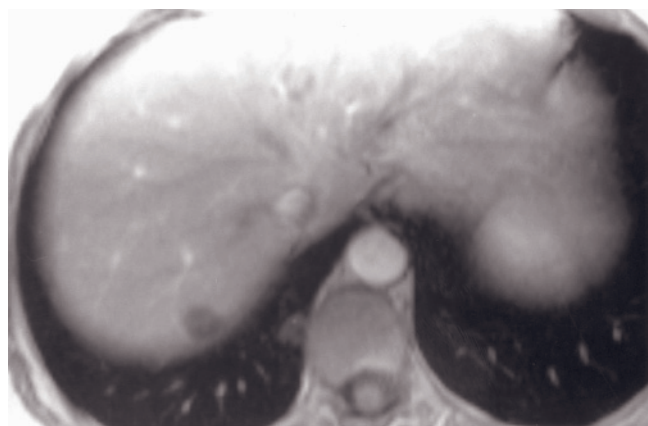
Multiple hemangiomas. T2-weighted fat-suppressed SS-ETSE (*a, b*) and immediate (*c, d*) and 90-s fat-suppressed (*e, f*) postgadolinium images. Multiple hemangiomas are appreciated throughout the liver. All of these lesions show increased signal intensity on T2-weighted images (*a, b*), peripheral nodular enhancement after contrast administration (*c, d*), and enlargement and coalescence of nodules on delayed postcontrast images (*e, f*), consistent with multiple hemangiomas.
